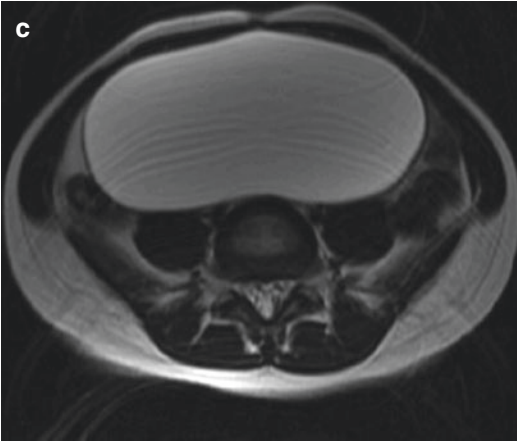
Abdominal ultrasounds in a newborn with prenatal suspicion of intraabdominal cyst. Postnatal ultrasound confirmed the presence of the 4.6 cm cyst, anechoic, uniloculated, thin-walled, in the right abdomen (a). One
